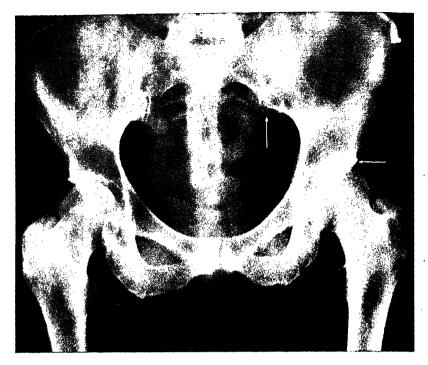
Radiograph of an adult pelvis. The upper arrow indicates the line of the sacro-iliac joint; the lower arrow points to the anterior inferior iliac spine.
